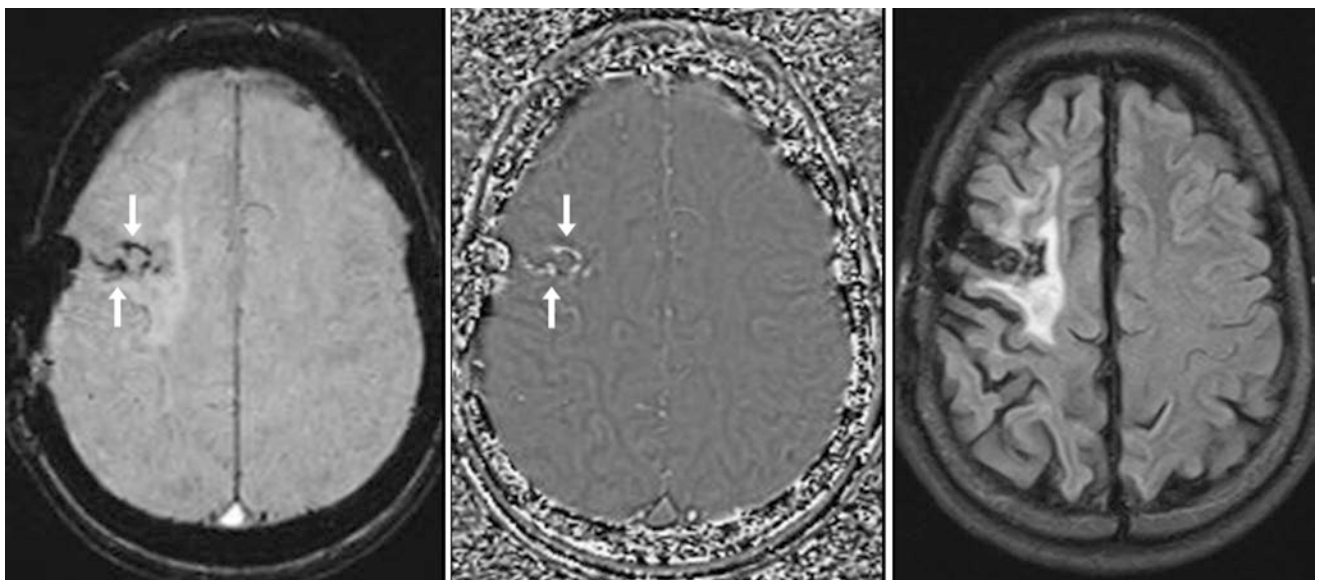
Example of hemosiderin (ferritin) outside of the basal ganglia: On a 1.5T left-handed MRI, a 28 year old had hemosiderin deposition (*arrows*) within a region of encephalomalacia (post-trauma) on
